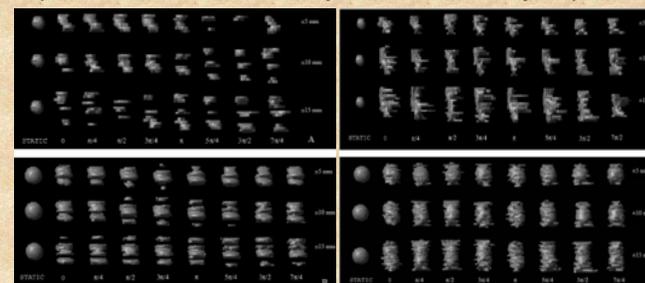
Volumetric distortion of a 10- (image set A) and 31.5- (image set B) mm diameter targets as a function of motion amplitude and initial motion phase for a fast or 1-sec (left) and a slow or 4-sec scan (right) CT imaging techniques.
